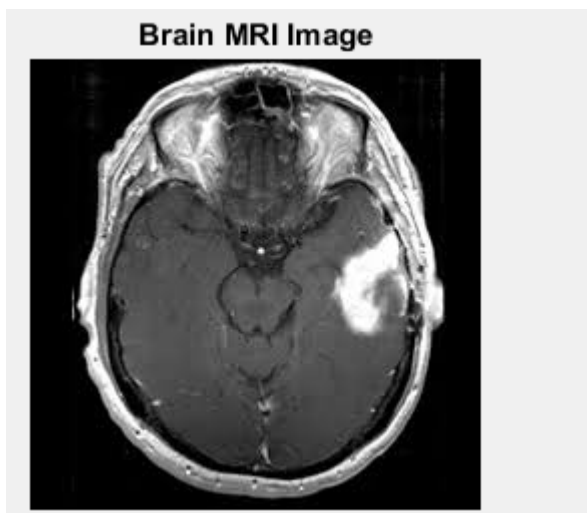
Input Brain MRI image
